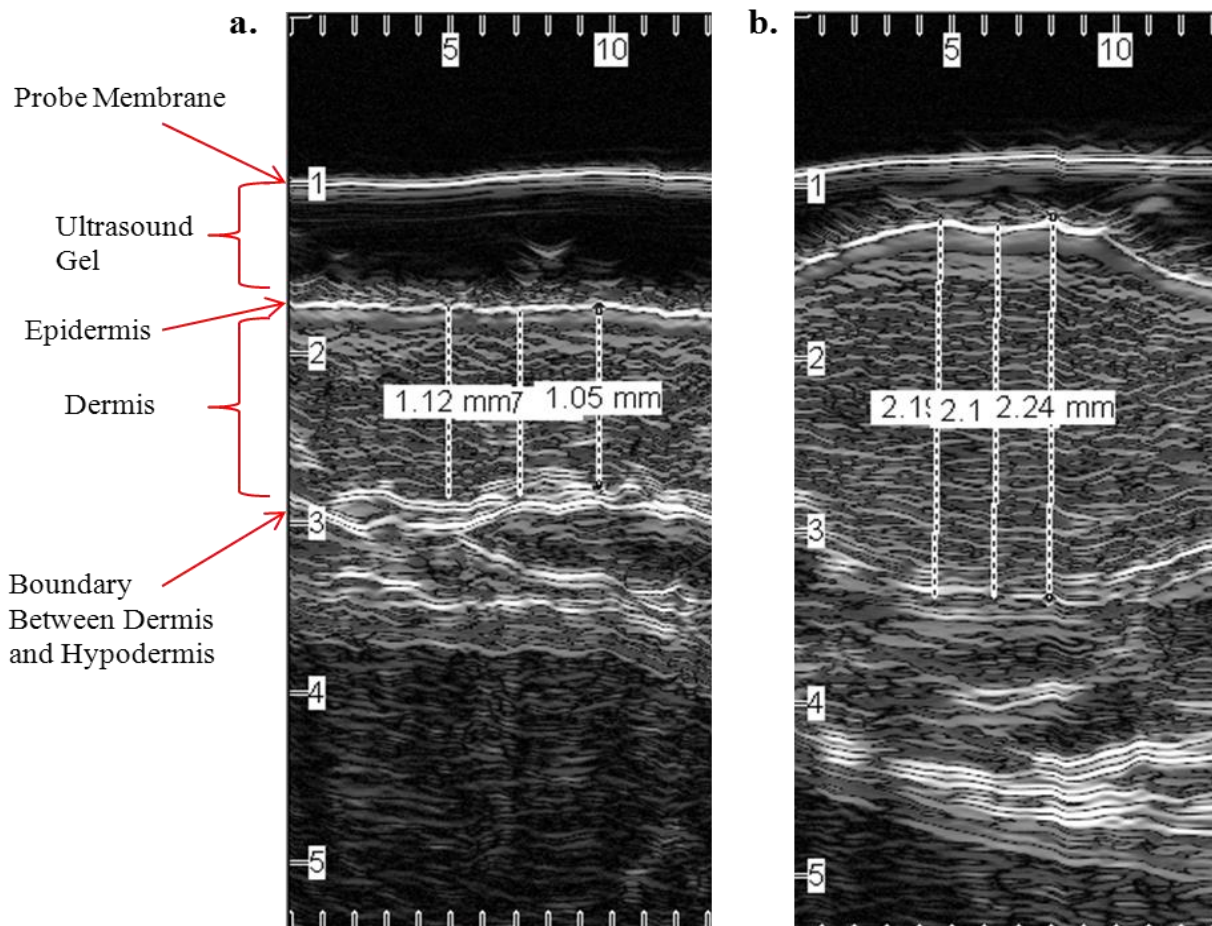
Typical high-frequency ultrasound scan images 48 h after elicitation at an acetone site (a) and a 0.0313% DPCP site (b) in a CON participant. The numbers across the horizontal axis are the distance across the skin surface (mm). The vertical lines indicate dermal thickness (mm).
